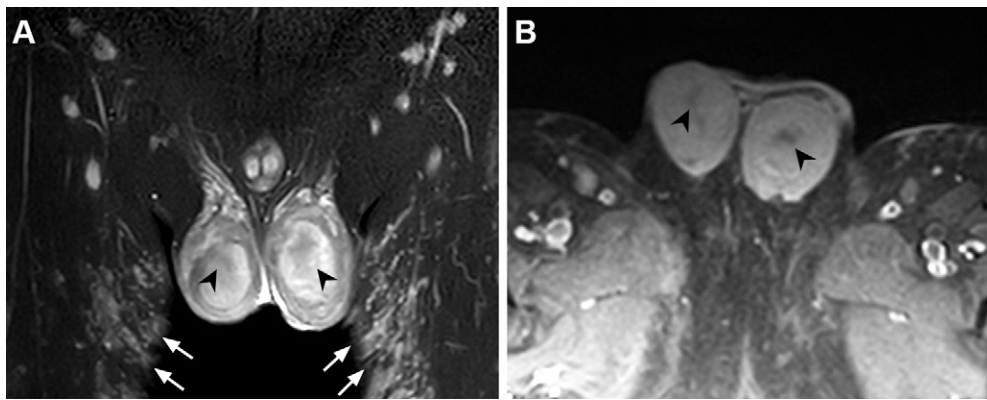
Testicular involvement in a 13-year-old adolescent boy. (A) Coronal fat-saturated T2-weighted MR image shows bilateral testicular enlargement and focal ill-defined hypointense lesions (arrowheads) in the parenchyma. Multiple small skin and subcutaneous lesions can be seen (arrows). (B) Postcontrast T1-weighted MR image shows heterogeneous enhancement of the testes with focal hypointense areas (arrowheads).
